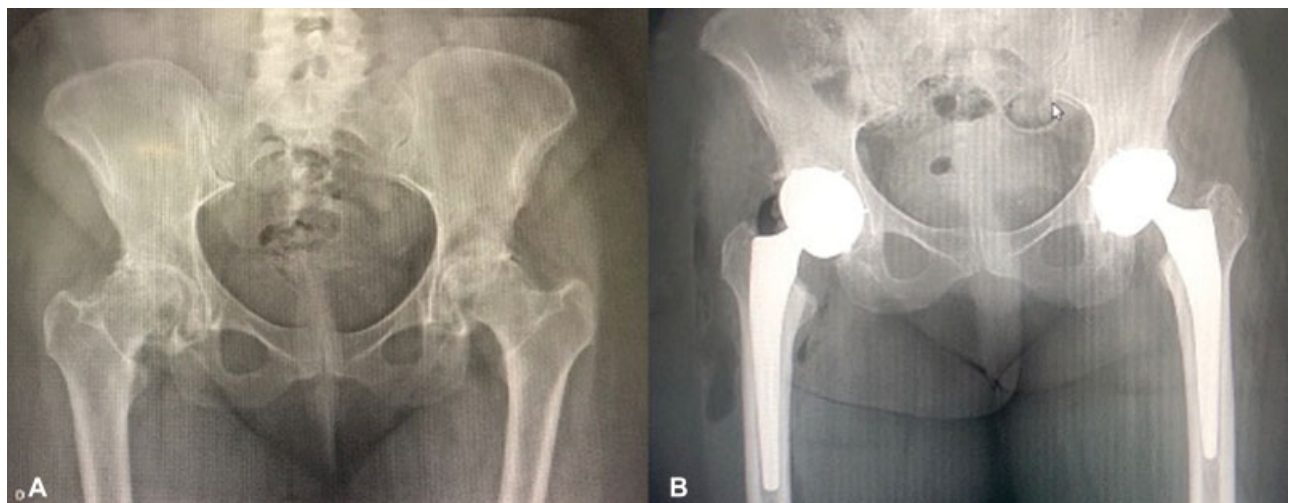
Anteroposterior pelvic radiograph of a 45-year-old female, with bilateral osteonecrosis of the femoral head (ONFH) (A), and postoperative cementless bilateral dual-mobility cup (DMC) (B).
